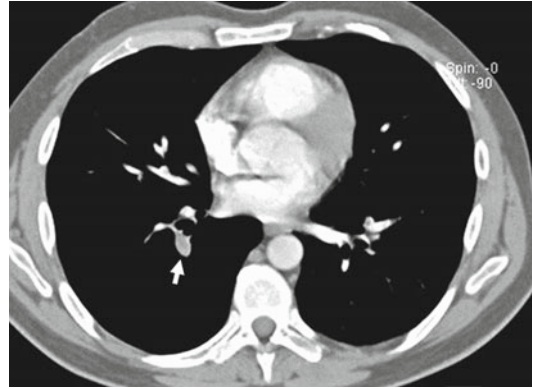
Enhanced CT scan shows an acute pulmonary embolus that causes a partial filling defect surrounded by contrast material “railway track” sign (*arrow*). One more acute pulmonary embolus affects the left main pulmonary artery (*arrowhead*)
